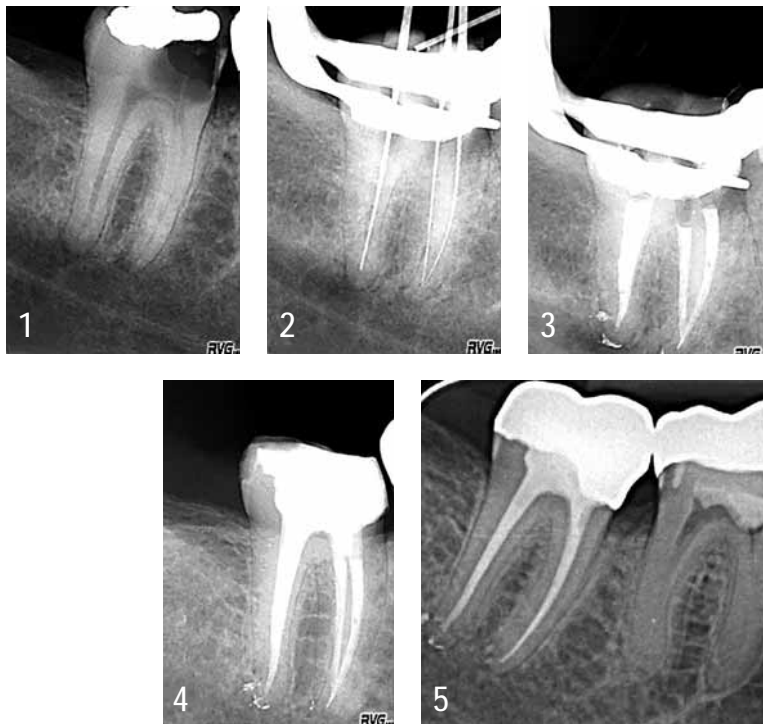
Initial radiograph, caries profunda, strong defect in substance and periradicular distal periodontitis.
